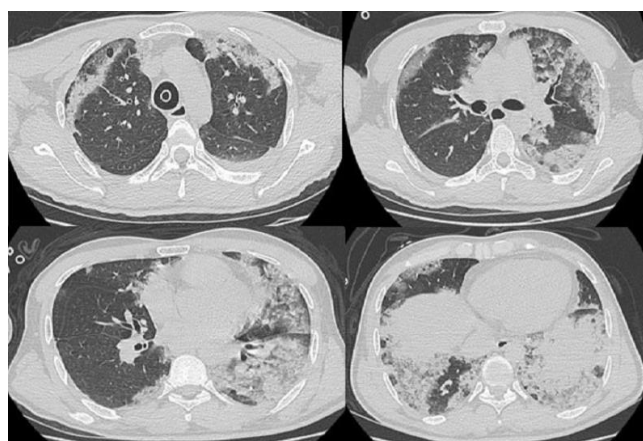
Bilateral diffuse ground glass and consolidated areas on thorax CT
